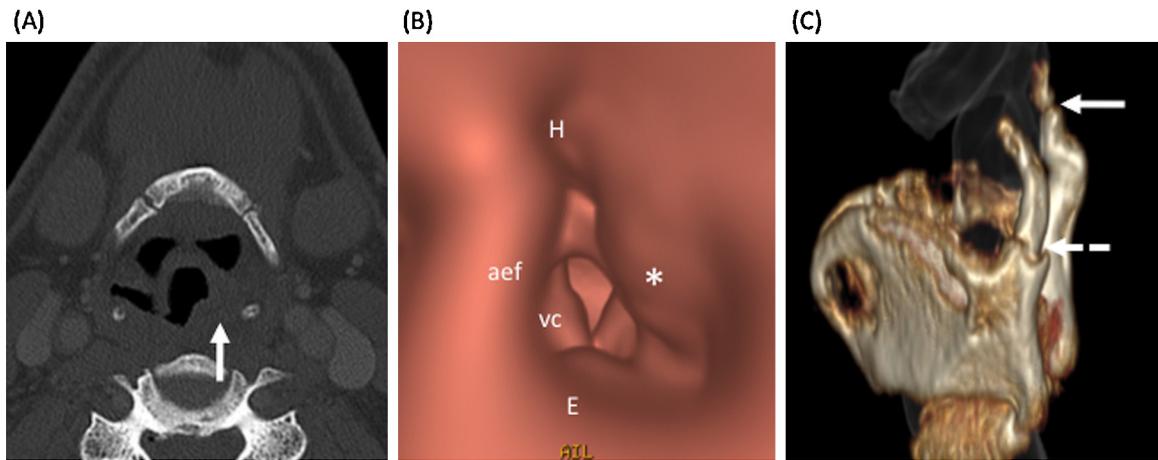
Horizontal fracture of the thyroid cartilage and characteristic hypopharyngeal hematoma caused by strangulation. (A) Axial CT image shows left hypopharyngeal hematoma (arrow). Note slightly abnormal position of left superior horn of the thyroid cartilage, which is shifted toward the midline. (B) VE image (view from above) shows mass effect of hematoma (asterisk) on the supraglottic larynx. E, epiglottis; H, hypopharynx; aef, right aryepiglottic fold; vc, right vocal cord. (C) Multilayer 3D VR (left oblique view) shows bilateral fractures of the superior horns of the thyroid cartilage (beige). Airway rendered in semitransparent white. Right fracture (solid arrow). Left fracture (dashed arrow).
